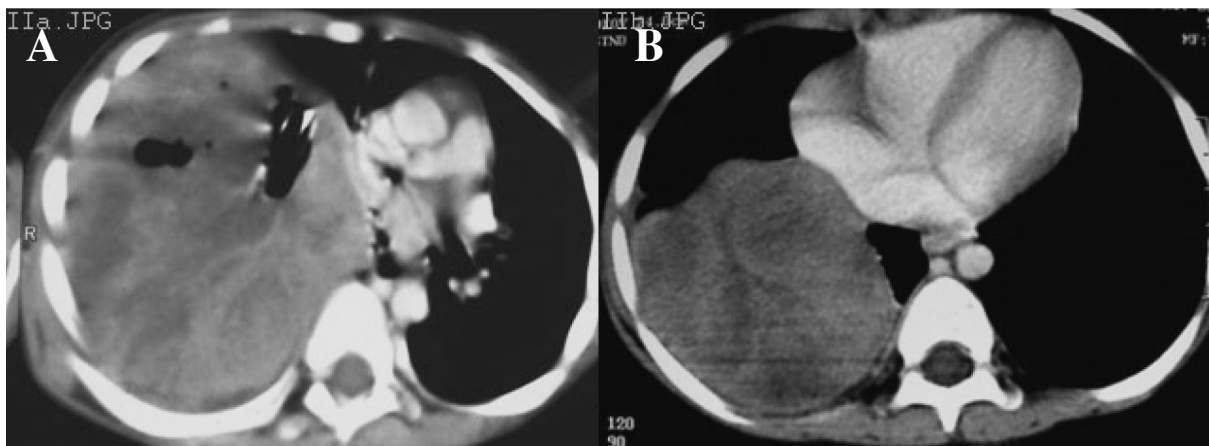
Computed tomogram of chest showing prechemotherapy (A) and post chemotherapy (B) tumor.
